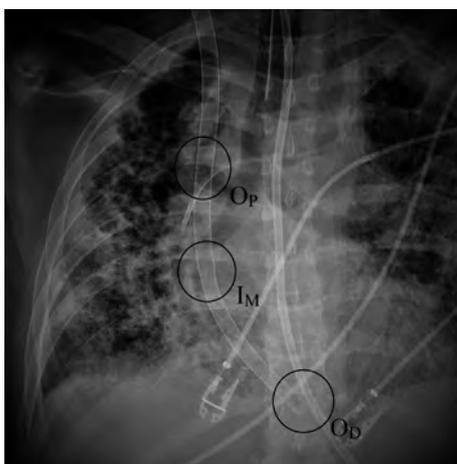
Chest radiograph revealing the cannula migration into the right ventricle, indicated by the distinctive displacement of the distal outflow port (OD) in medial direction as well as the caudal shift of both the proximal outflow port (OP) and the medial inflow port (IM).
